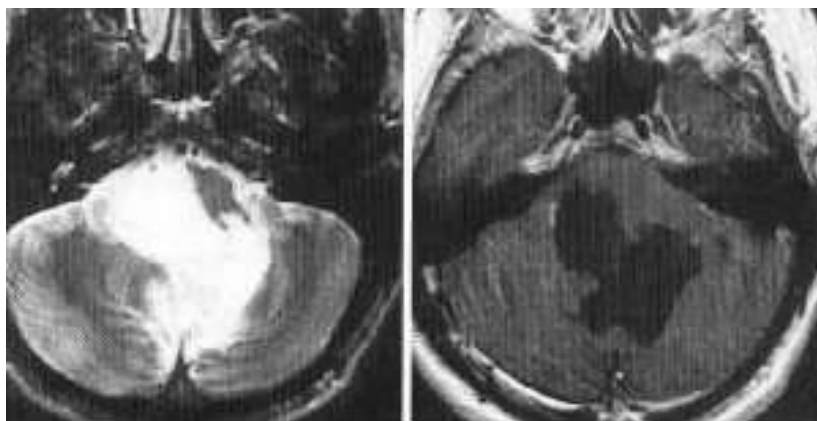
Epidermoid is seen on T2 and T1 MRI[8]
